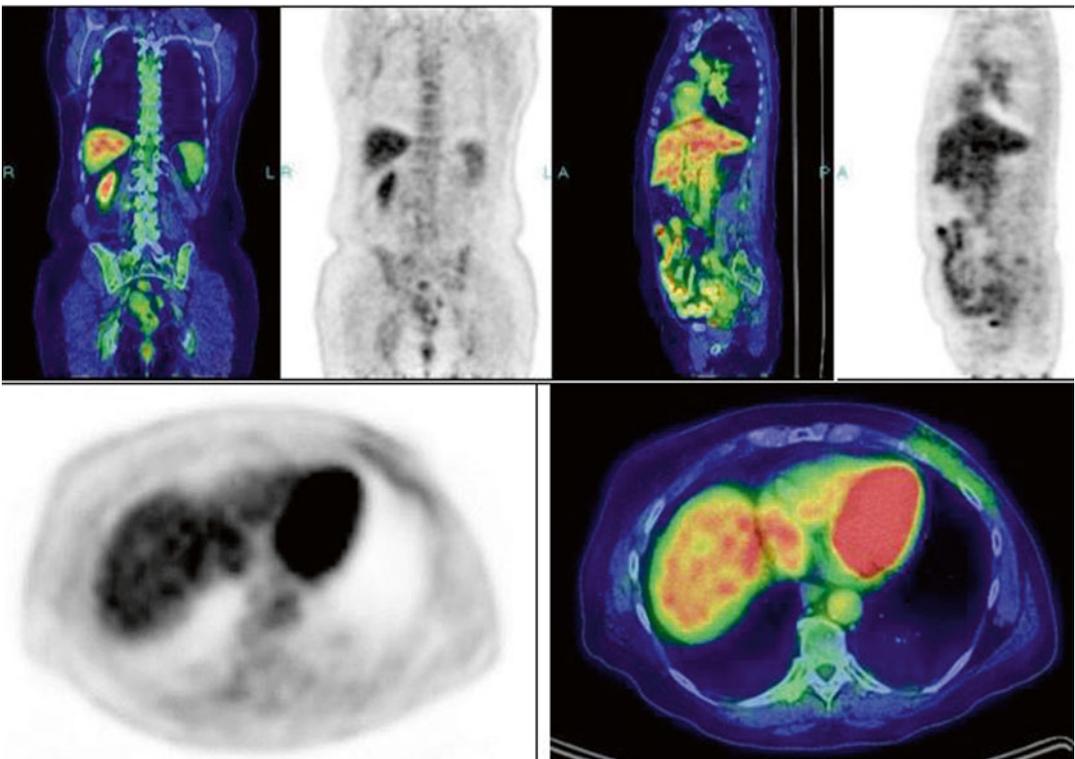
PET/CT (posttreatment/surgery)
